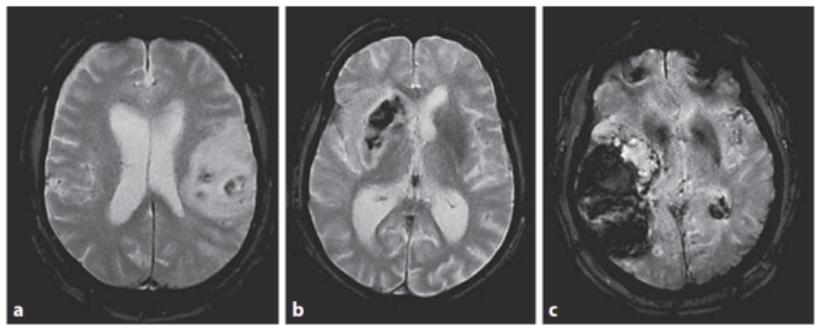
The three categories of HT on T₂*-MRI: petechial (a), confluent (b) and space-occupying (c).
